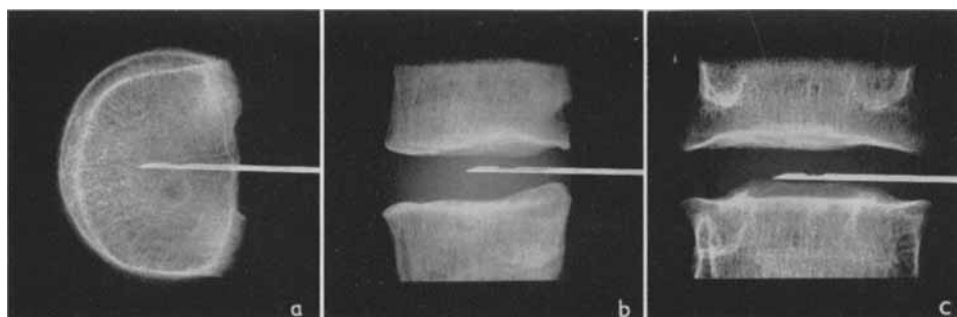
Roentgenographic appearance of the disc 298/58 - L 3, shown in fig. 14. Classified as normal (0). Scale 1:2.
